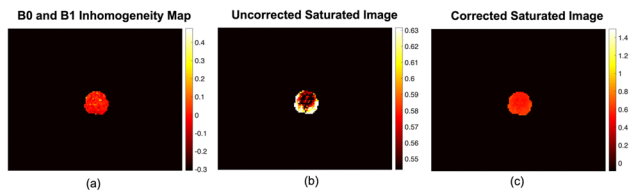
a inhomogeneity map of the prostate gland derived from WASABI, b uncorrected and c corrected CEST MR image
